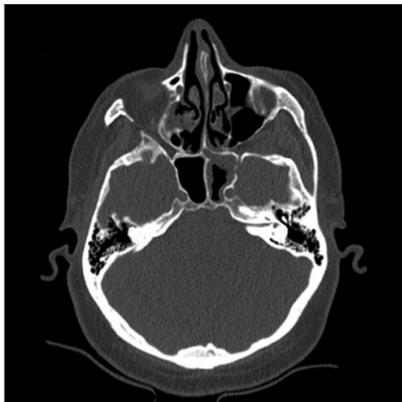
Computed tomography scan, axial view, without contrast enhancement. Mucosal thickening of the left sphenoid sinus is apparent. Possible dehiscence is demonstrated along the lateral wall of left sphenoid sinus.
